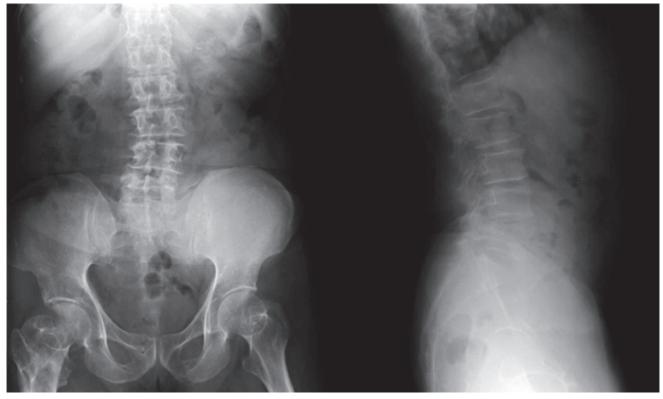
Plain radiograph of lumbo-sacral spine (AP and Lateral views) did not reveal any obvious bony mets. Mild lumbar scoliosis was noted
